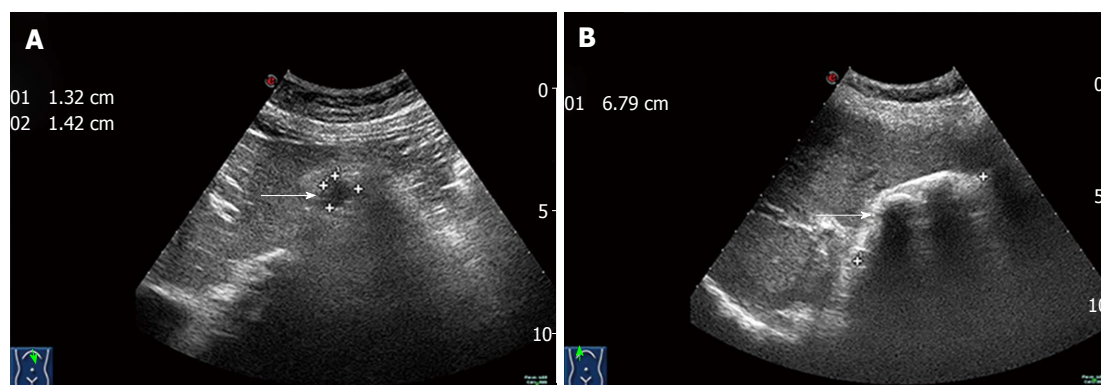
Ultrasound findings. A: Ultrasound revealed a 1.4 cm × 1.3 cm, well-defined cystic lesion (arrow) in the pancreatic body; B: A 6.8 cm sized strong echo (arrow) was shown in the gallbladder.
